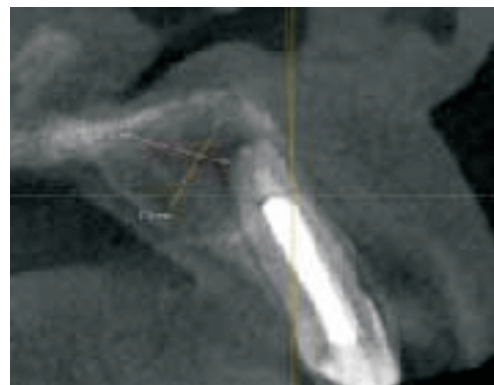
CBCT image of lateral incisor after 6 months
